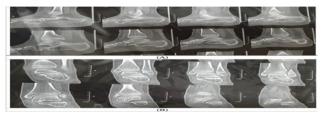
(A): Coronal MRI showing severe peritalar bone marrow edema; (B): Sagittal MRI showing severe peritalar bone marrow edema.
